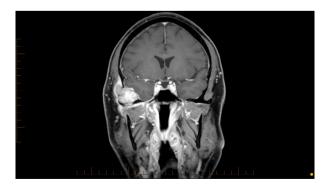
Postgadolinium magnetic resonance imaging demonstrating an expansile mass on the inferolateral surface of the right squamous temporal bone.
